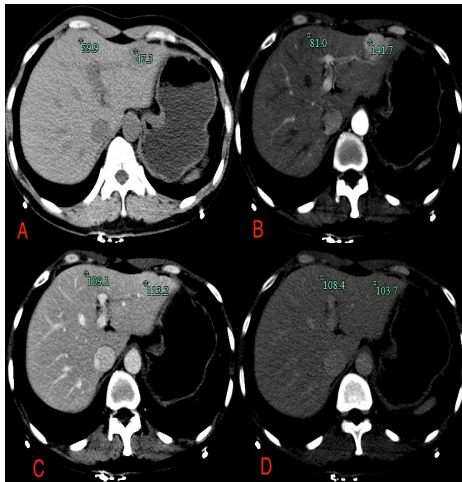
Images in a 39-year-old man with FNH. The CT enhanced scan of liver: there is a round slightly low-density lesion with a size of approximately 3.0 cm * 2.1 cm, uniform density, and clear boundaries in the hepatic II segment; and the lesion in AP(B) was obviously uniform enhanced with high-density (Δ HU =60.70HU, CVR=1.75), the enhancement was reduced in PP (C) and DP (D) to iso-density, and the Δ HU are 4.10HU, -4.70HU and CVR are 1.04, 0.96, respectively. FNH: Focal nodular hyperplasia, CVR: CT value ratio, Δ HU: CT value difference, AP: arterial phase, PP: portal phase, DP: delayed phase.
